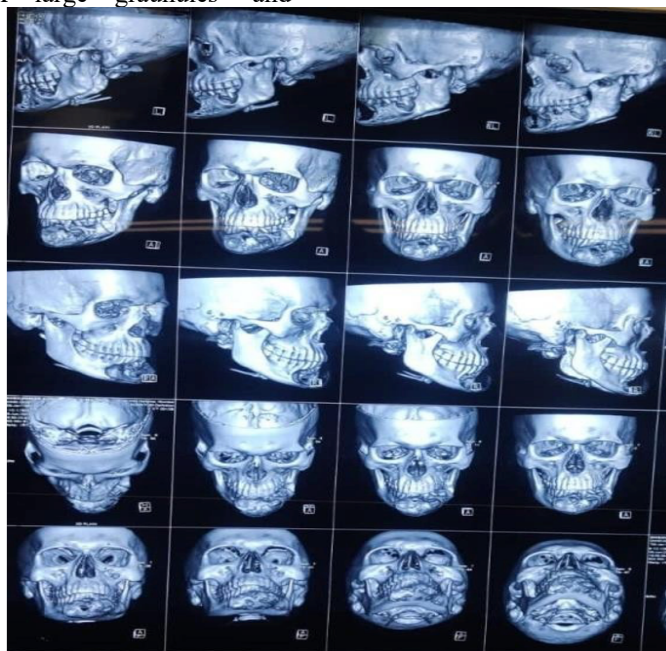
CT scan showing expansion showing extent of the lesion.
